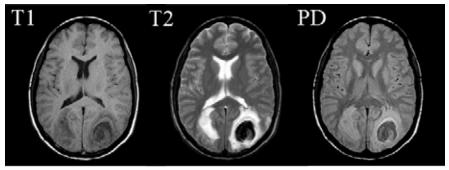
Types of MRI scans
